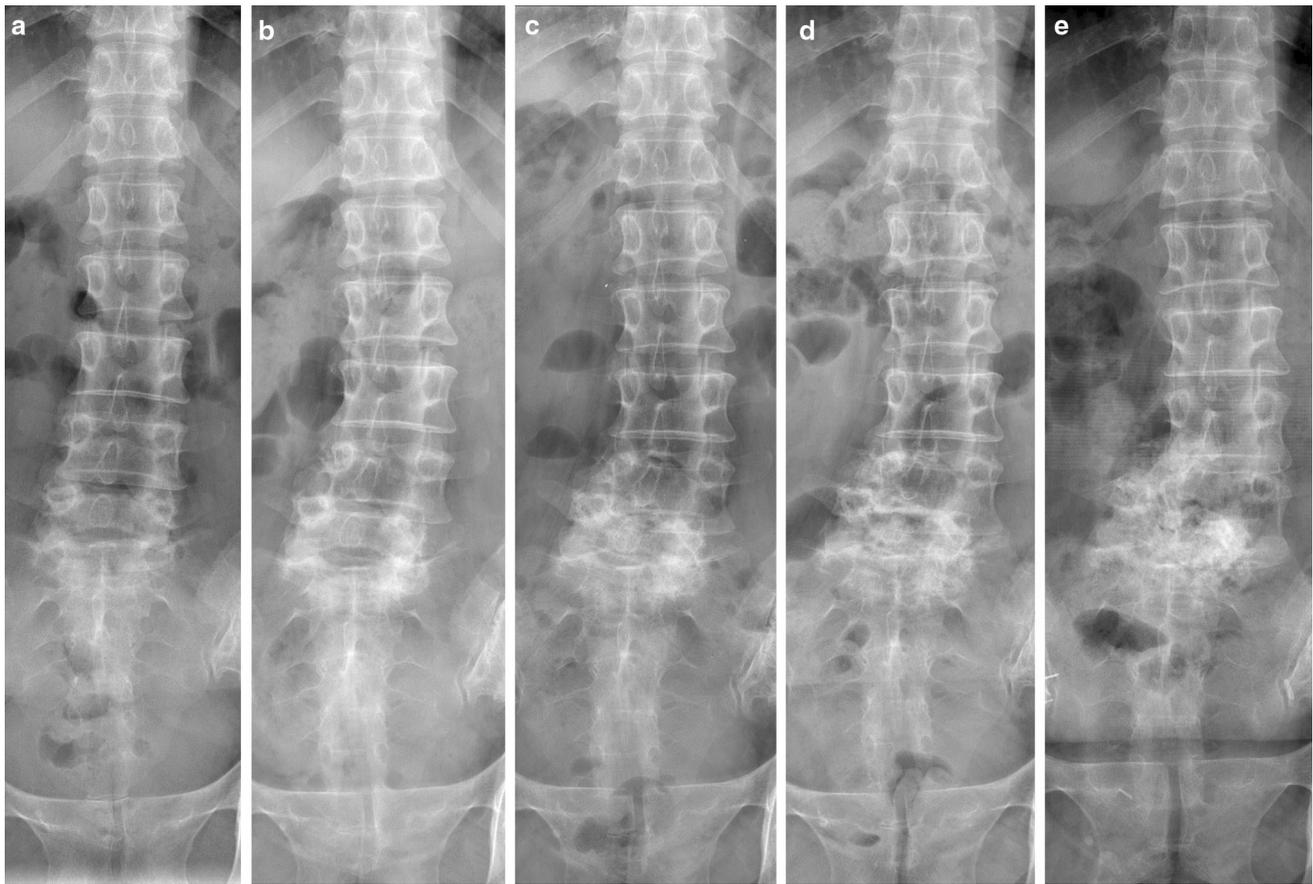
Serial anteroposterior lumbar radiographs show progressive dislocation at L4–5 and L5–S1. a At initial visit 8 years before surgery, b 5 years before surgery, c 3 years before surgery, d 2 years before surgery, and e at the time of surgery
